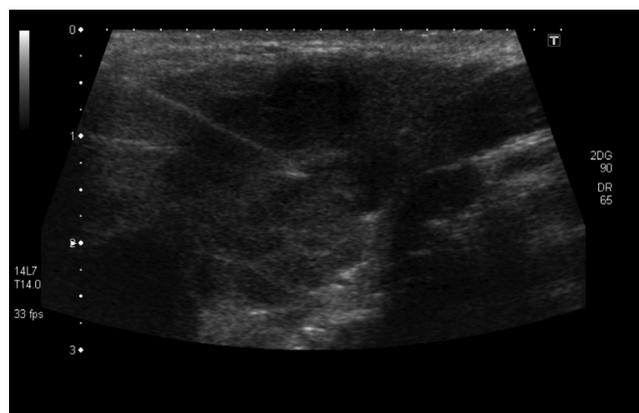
FNCC of a parotid gland under ultrasound guidance. The fine needle is seen within the tumor (on the upper left).
